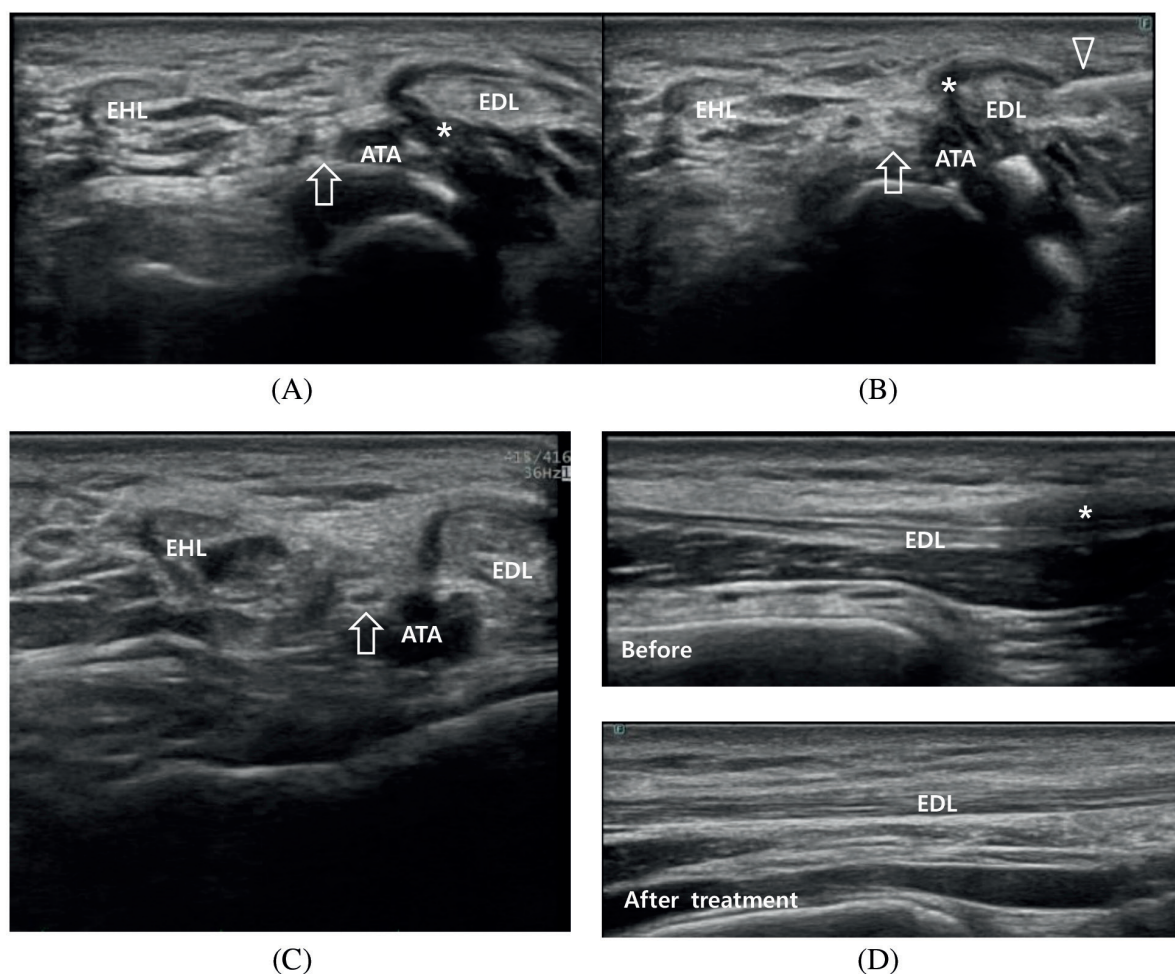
Ultrasound of left ankle. (A) Extensor digitorum longus (EDL) tendon with focal tenosynovitis (asterisk) on initial examination in short-axis view. Note normal deep peroneal nerve (arrow) and anterior tibial artery. (B) Ultrasound-guided injection within tendon sheath by needle tip (arrowhead) in short-axis view. Note that the deep peroneal nerve (arrow) is not infiltrated by lidocaine. (C) Short-axis view 1 month later with decreased hypoechoogenicity and tendon sheath fluid surrounding the EDL. (D) Long-axis view before and 1 month after treatment shows resolution of EDL tenosynovitis.
